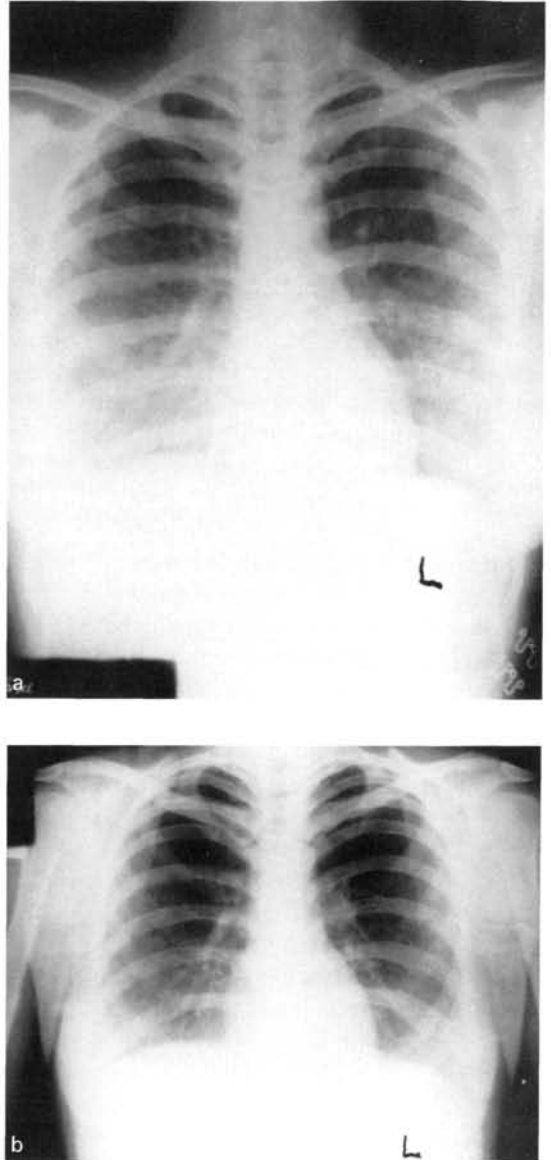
a) Bilateral haziness and ground glass appearances on chest roentgenogram suggesting acute lung injury seen in a young girl with severe distress and acute respiratory failure. b) Chest roentgenogram of the same patient after 72 hours of oxygenation and mechanical ventilation: showing almost clear lung fields.
